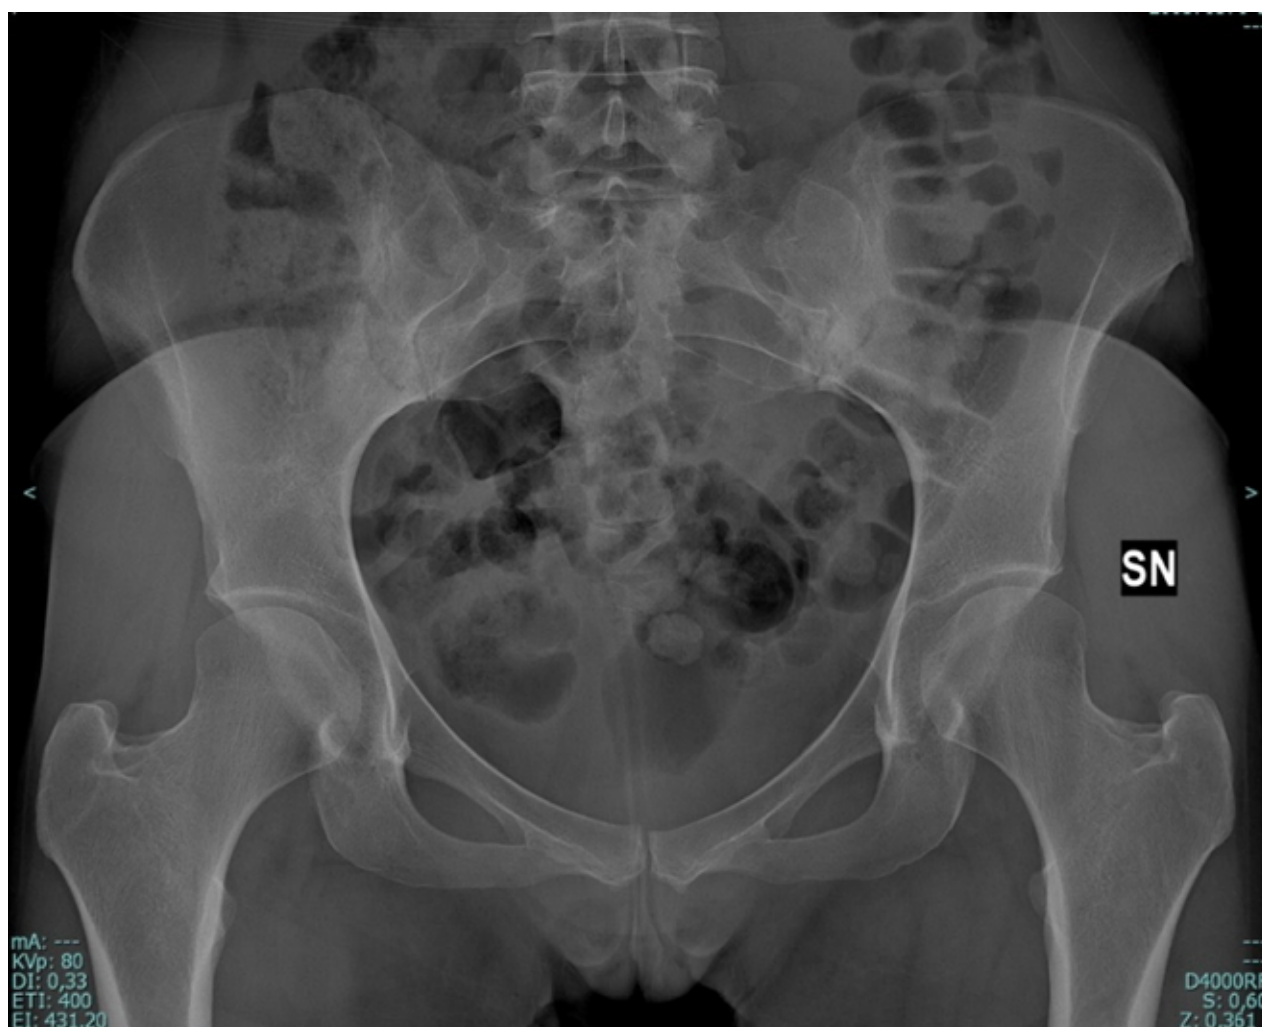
Pelvic X-rays shows bone sclerosis of bilateral subcortical articular surface of the iliac bone.
